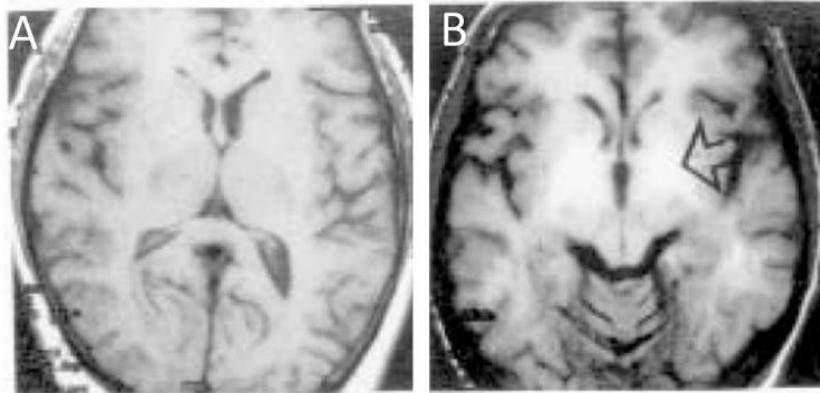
MRI of a healthy control (A) and an alcoholic cirrhotic patient of the same age (B). the arrow show abnormally bilateral hyperintensity signals in the globus pallidus. Such abnormality is due to Mn deposits (modified according to (Lockwood *et al.*, 1997).
